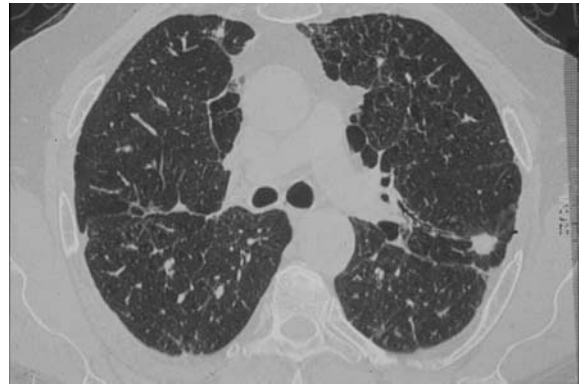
Subcarinal high-resolution CT section in Wegener's granulomatosis, showing small nodules, septal and non-septal lines, suggestive of granulomatous lung disease.
